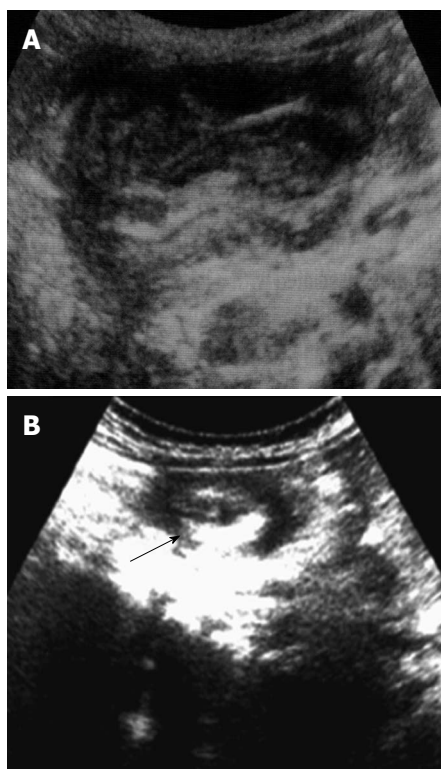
“Pseudokidney” sign (A) and “target sign (arrow)” (B) on ultrasonography.
